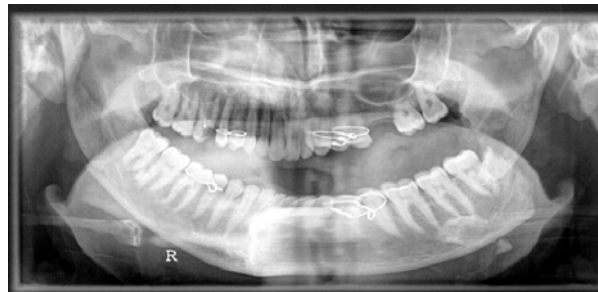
Panoramic radiograph of bilateral angle fracture (sever displacement of the left , side not associated with third molar)
